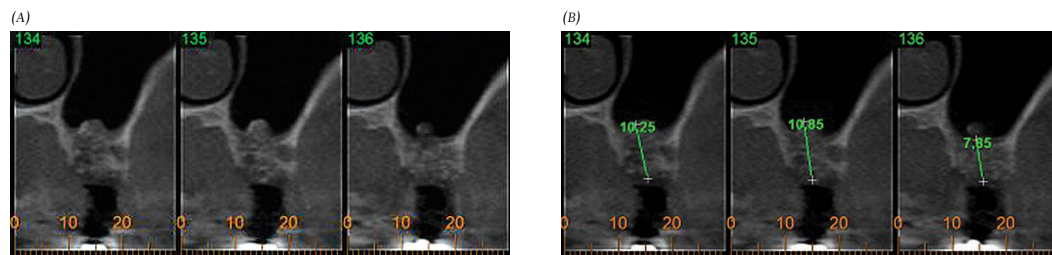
A) Post-operative cone beam computed tomography. B) Post-operative cone beam computed tomography with measures that evince bone height gain near 3 mm.
